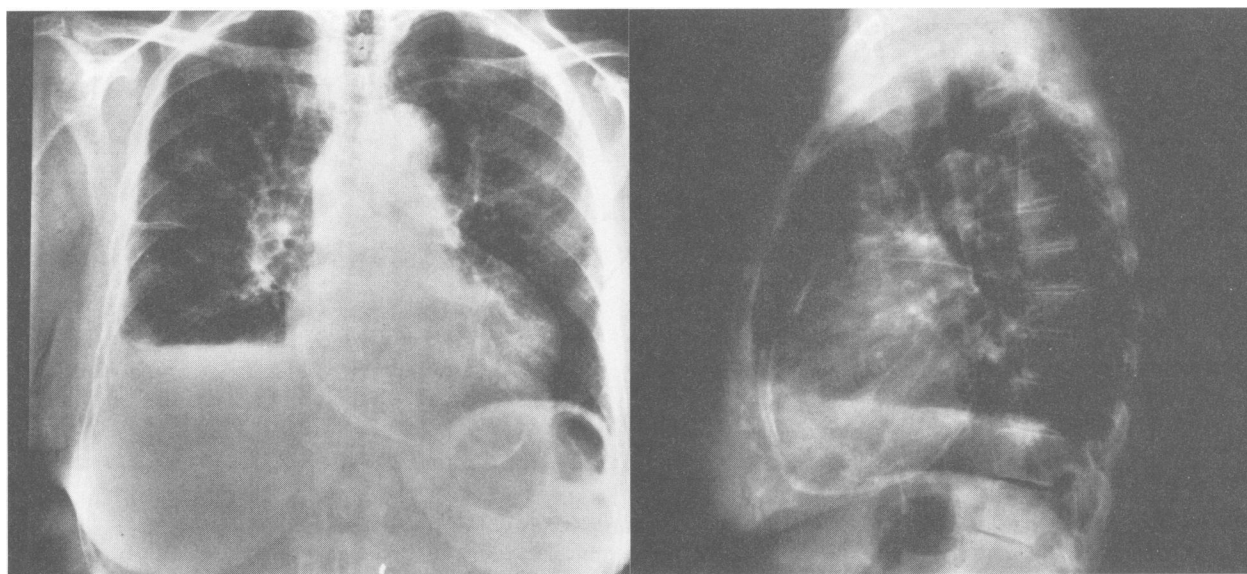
Posterior-anterior and lateral chest radiograph demonstrating a thickened calcified pericardium in another patient with CP (Courtesy of Paul Stark).
